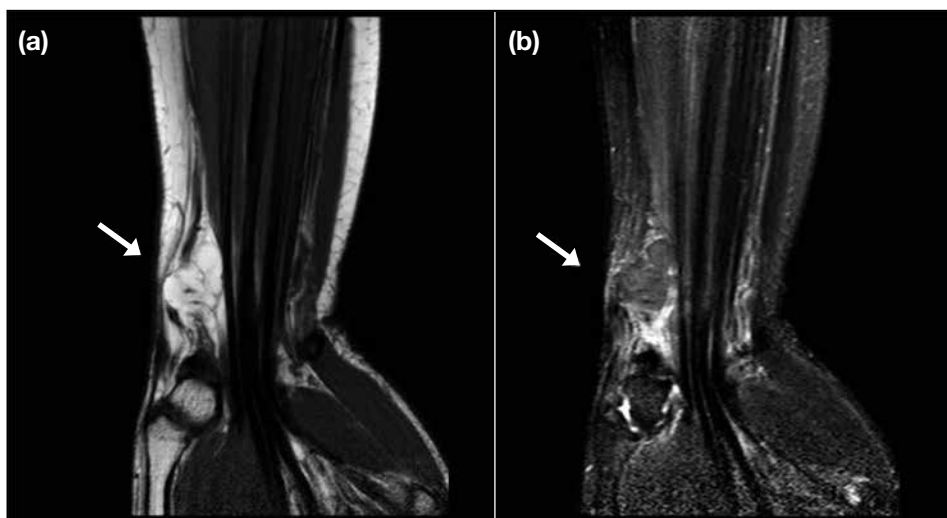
Lipoma in a 56-year-old man who presented with swelling at the radial volar aspect of the left wrist: (a) T1-weighted coronal magnetic resonance image showing a multilobulated hyperintense subcutaneous lesion (arrow). (b) Short-tau inversion recovery coronal magnetic resonance image showing signal intensity drop of the corresponding lesion.
